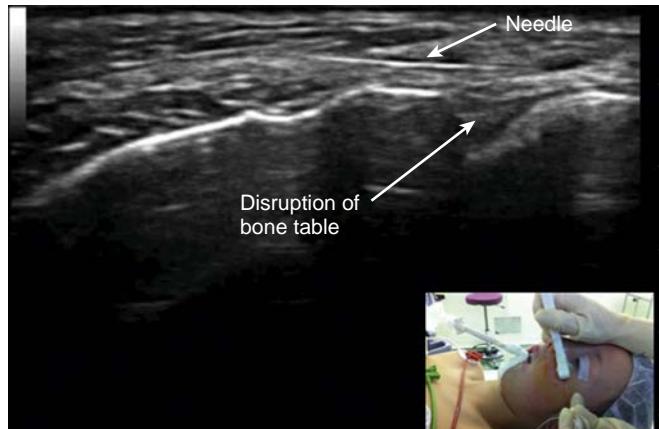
Ultrasound of infraorbital nerve block and probe position on face. Disruption of bone table indicates foramen of trigeminal nerve.
